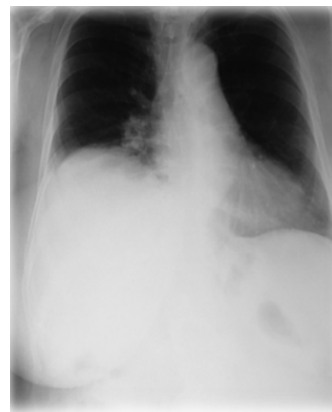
Chest X-ray imaging shows the elevation of the right hemidiaphragm.
